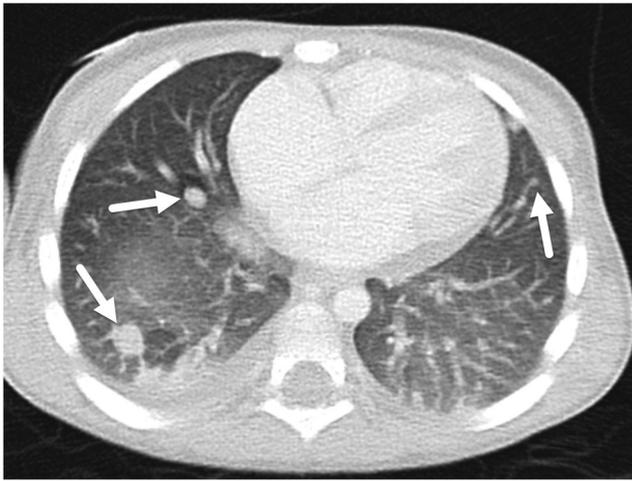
Pulmonary metastases. Axial chest CT in a child with hepatoblastoma shows multiple pulmonary metastases (*arrows*). The largest nodule in the right lower lobe measures approximately 1 cm in diameter
